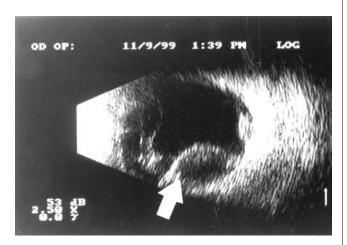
Ocular ultrasound scan showing suprachoroidal haemorrhage
